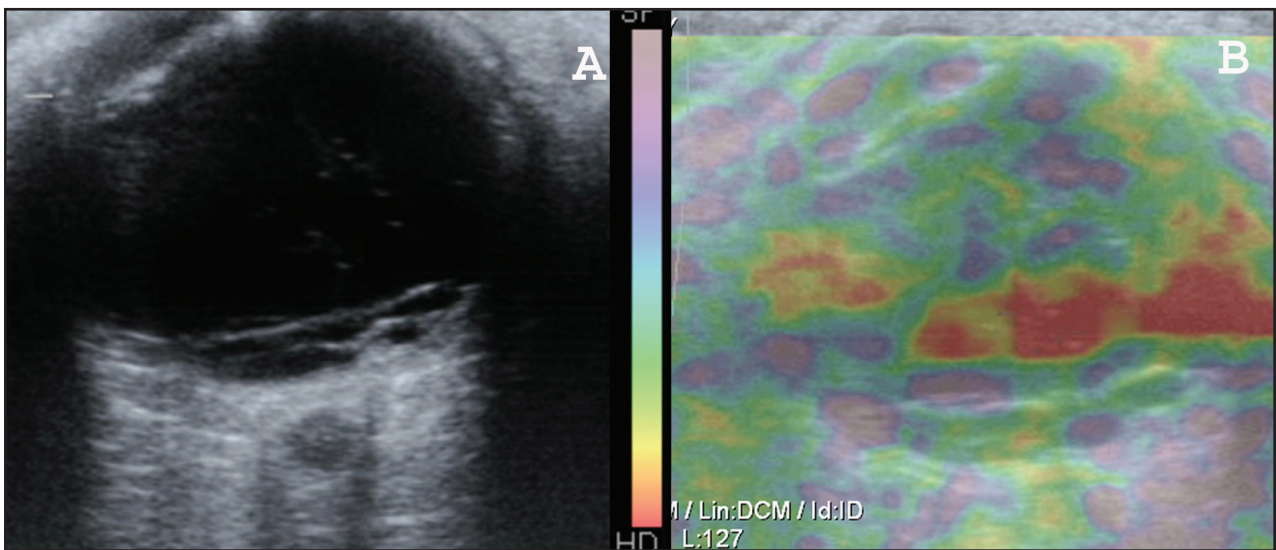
Color-coded ultrasound transverse elastographic image of the same eye presented in Figure 3 (B) and corresponding B-scan image (A). The color scale from blue (more elastic) to red (less elastic) is shown between A and B.
